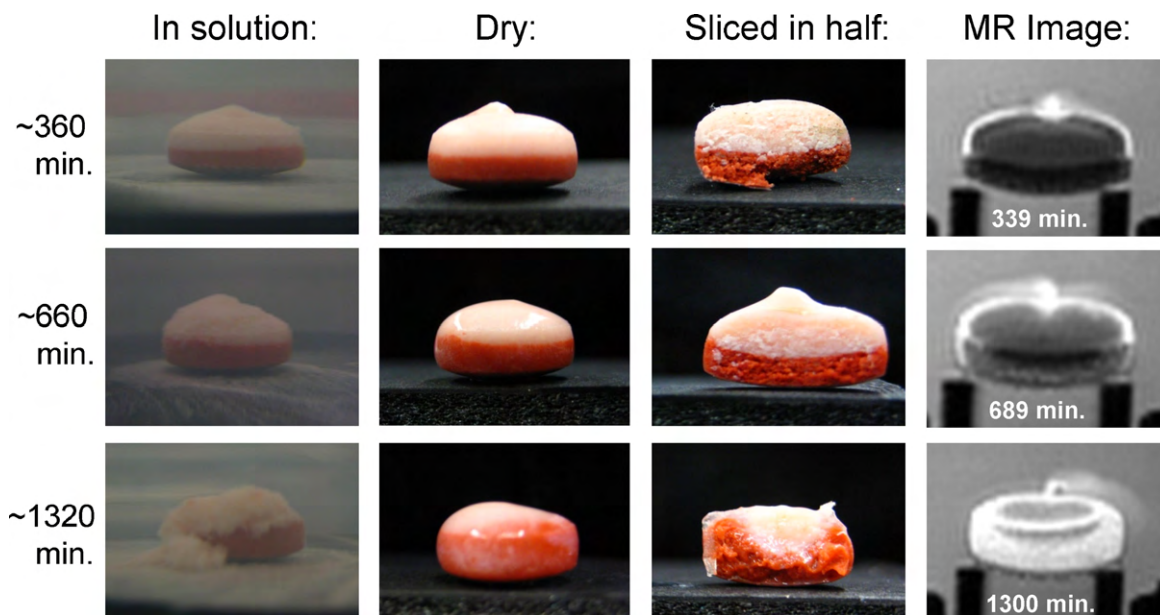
Comparison of the trial 1 Cardura XL tablet MR images (far right) to digital images of a tablet (in 500 mL of deionized water in a glass beaker) corresponding to the same soaking times. Images from left to right: tablet soaking in beaker of water; tablet after removing it from the water; cross-section of tablet after slicing it in half longitudinally; MR image of tablet placed in MR tablet holder at corresponding hydration time. Corresponding features in the images include the drug suspension deposited on the upper surface of the tablet, clear distinction between the drug and sweller layers, and swelling of the sweller layer.
